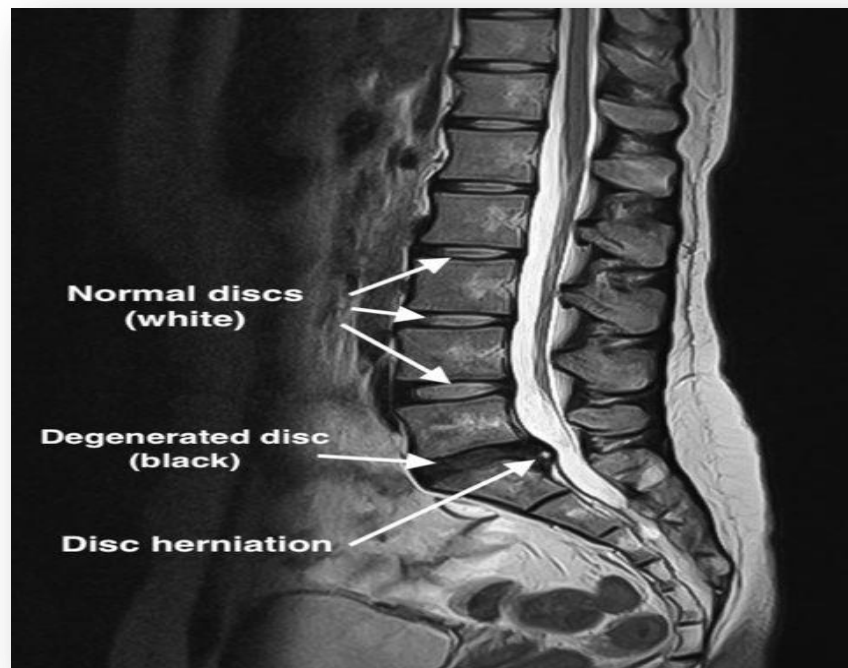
MRI for lumbar disc herniation (35).
